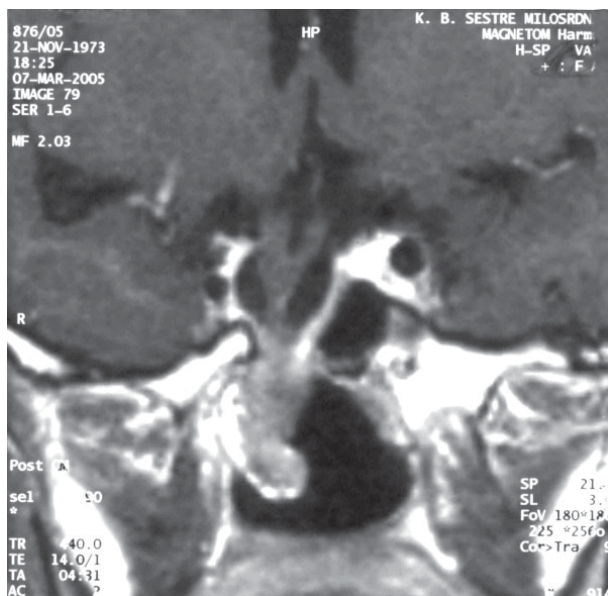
MR image of the sellar and parasellar region in the patient with transsphenoidal encephalocele (coronary section, T1).
